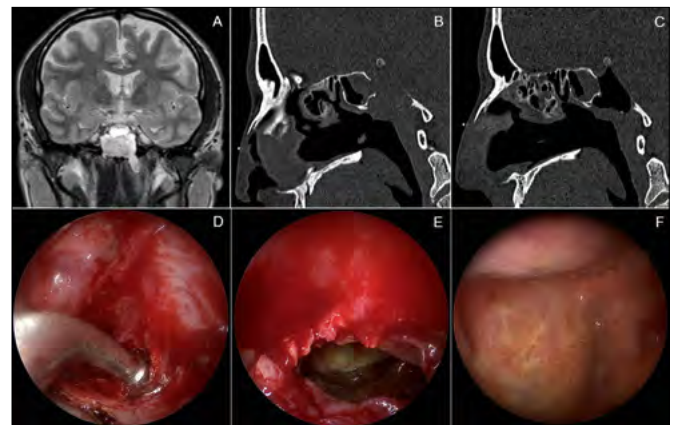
Images of a 46 years-old man who developed headache and photophobia due to a cholesterol granuloma. MRI revealed a sphenoid-clival growing lesion, with regular margins and 45 mm of diameter. The mass was hyperintense on T1 (A), iso-hyperintense on T2 and determined an elevation of the pituitary gland, with no signs of infiltrations of surrounding structures. A basal CT confirmed the presence of osteolysis of the posterior sphenoidal wall replaced by a mass of 29 x 30 mm (B). Swelling of the nasopharyngeal roof was seen, through nasal endoscopy. An endoscopic transsphenoidal approach was made to reach the posterior sphenoidal wall where the cystic lesion was drained (D, E), with no sign of CSF leak. Postoperative endoscopic view with sella and ICAs visible through the thin clival bone left (F). A CT control 24 hours later showed no postoperative complications (C).
